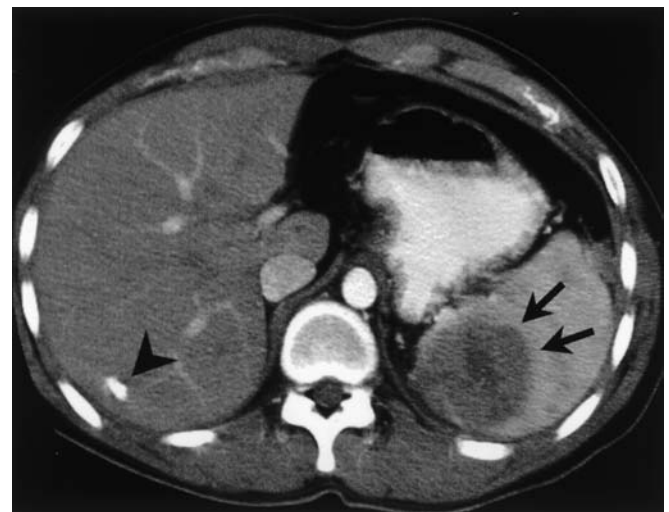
Splenic metastasis. The CT scan shows a round hypoattenuating mass (*arrows*) in the spleen. Note a small Lipiodol-laden nodule in the right lobe of the liver (*arrowhead*)
